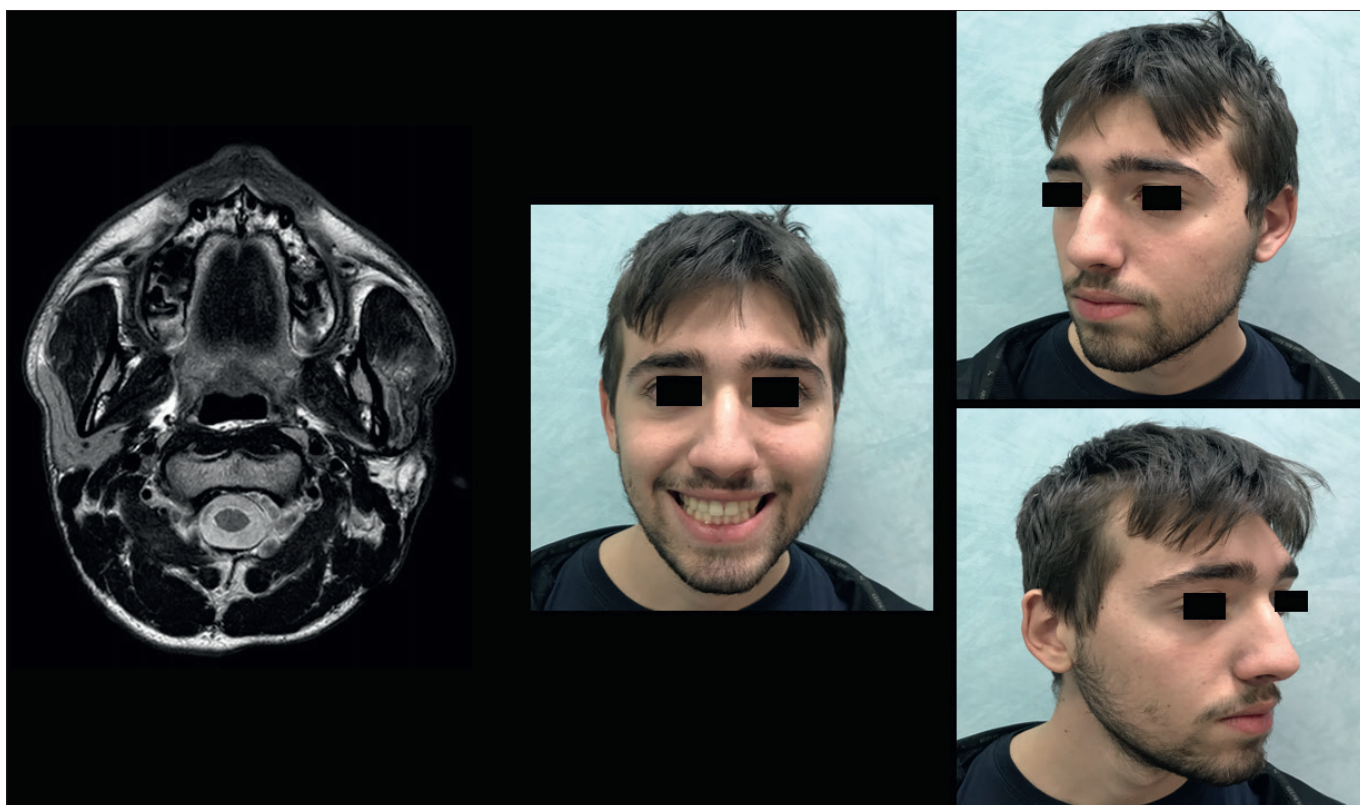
Neck MRI (T2) at 2 years postoperative and aesthetic outcomes in 16-year-old male.
